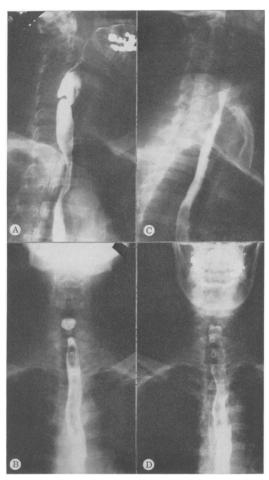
Esophageal roentgenograms in patient with small pharyngo-esophageal diverticulum. A and B, Before operation. C and D, Five days after esophagomyotomy.
